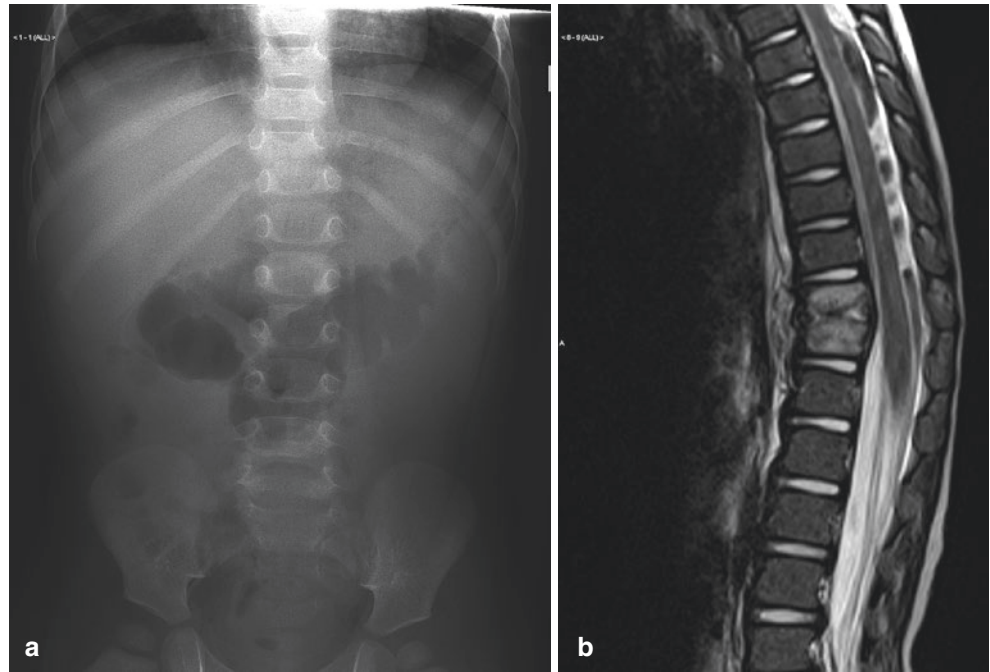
Plain X-ray showing osteitis of the mid-thoracic vertebral column
